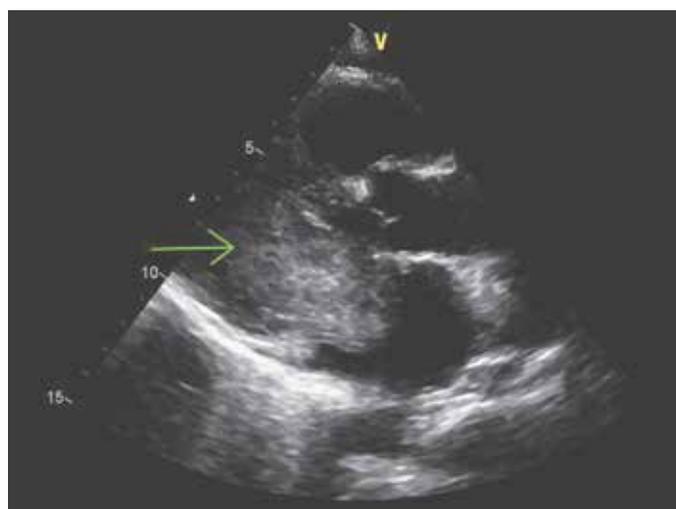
Transthoracic echocardiography (a long-axis view) showed a huge left atrial myxoma (arrow) prolapsing into the left ventricle in a 56-year-old female patient presenting with fever of unknown origin
